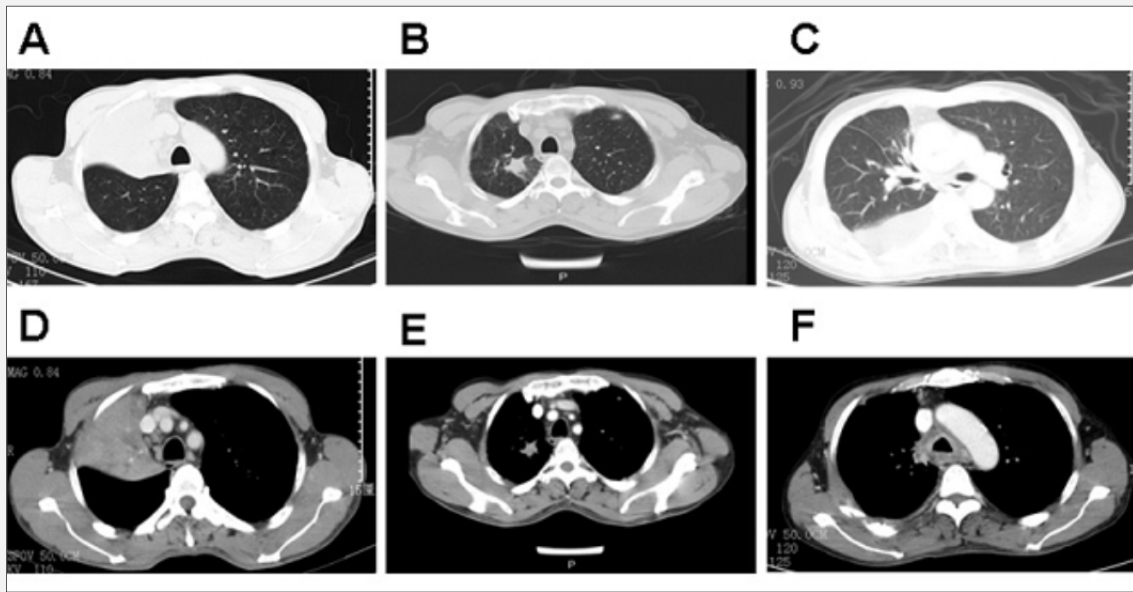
CT scan of the patient.
